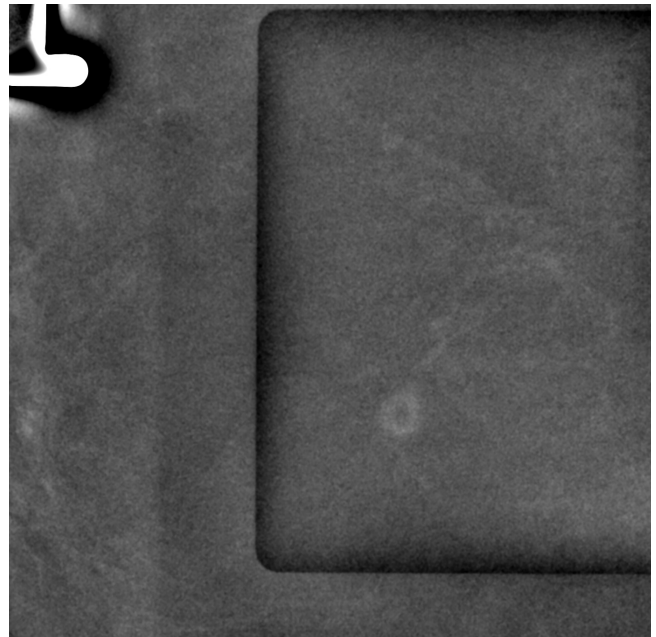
Scout image. Rim enhancing mass at 12:00 in the right breast detected in a patient with suspicious finding on preoperative breast MRI.
